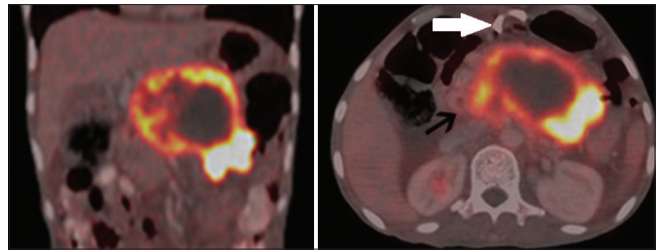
Positron emission tomography-computed tomography: Intense fluorodeoxyglucose uptake (maximum standardized uptake value 10.8) in the periphery of hypodense lesion in the pancreas (black arrow). A percutaneous catheter is also noted (white arrow)
